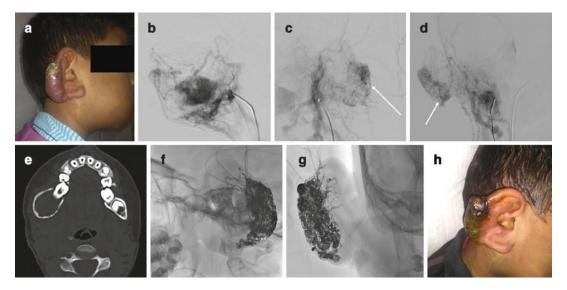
Direct puncture onyx. (a) Clinical photograph of a young boy with pinna AVM presented with bleeding from the pinna. (b) Catheter angiography in oblique view showing incidentally detected high flow dental arcade intraosseous mandibular AVM. CAMS is a known association with Maxillofacial AVMs. This patient belongs to CAMS 3. (c) Lateral and (d) AP view showing the Pinna AVM. (e). CT Mandible showing lytic lesion. The parents did not want pinna excision hence definitive
